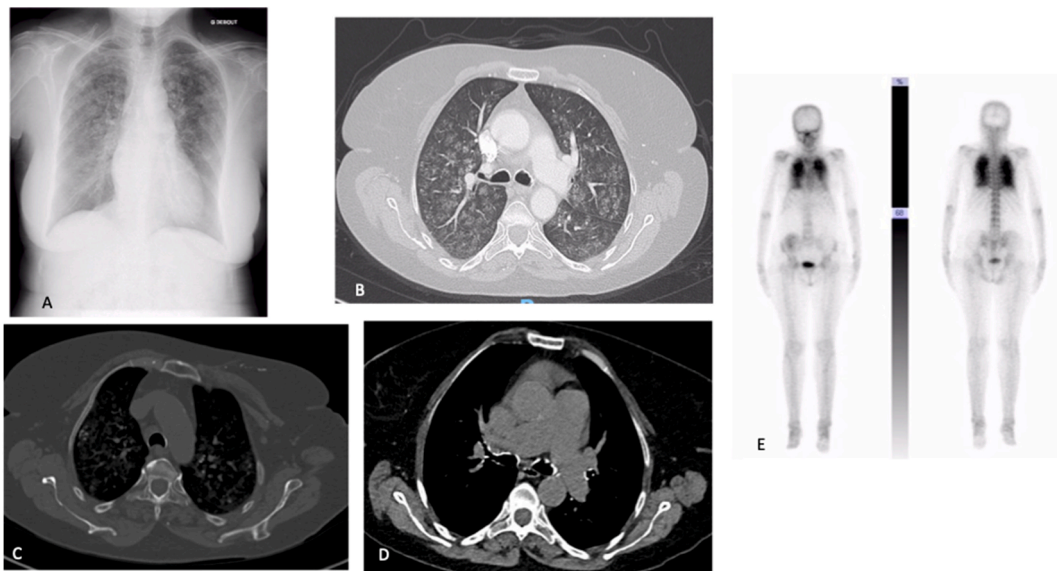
Patient's imaging: A/chest X-ray with diffuse bilateral opacities, predominant in the upper lobes, B and C/chest computed tomography (CCT) with diffuse centrilobular micronodules, respecting subpleural, fissural and peribronchovascular spaces (parenchymal and bone windows respectively), D/CCT (mediastinal window) showing calcified tracheobronchial tree E/bone scan with bilateral lung fixation.
